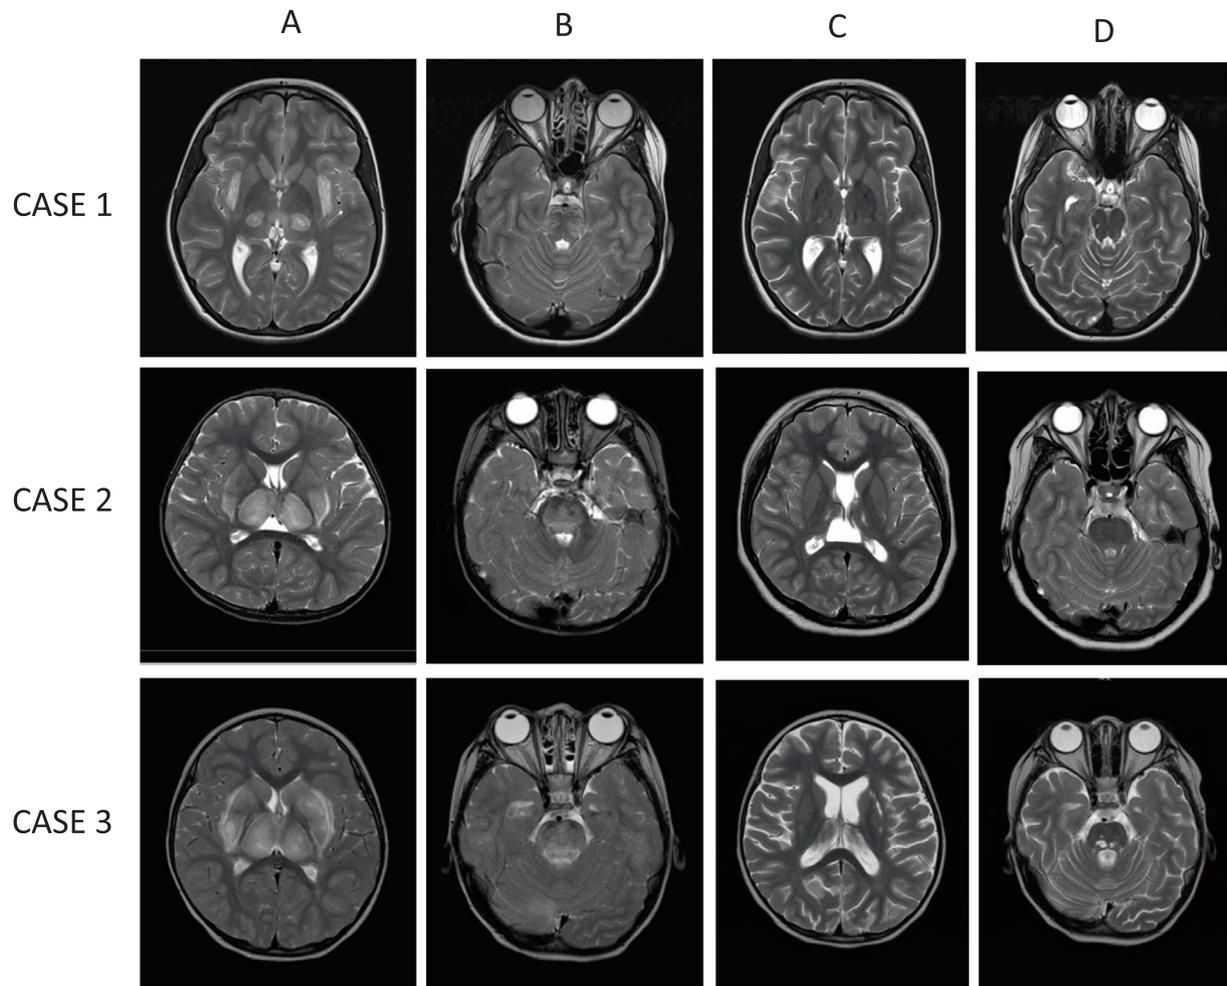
Acute and Convalescent MRI for Cases 1, 2 & 3. Case 1: Axial T2 Weighted MRI scans for the three cases. A: acute through thalamus. B: acute through brainstem. C: convalescent through thalamus. D: convalescent through brainstem. Case 1 (A) – Swelling and hyperintensities noted in bilateral external capsules, lateral putamina and thalami on acute MRI; Case 1(B) – Hyperintensities noted in the midbrain on acute MRI; Case 1 (C) – Resolution of T2W hyperintensities with atrophy of the thalami and some T2W hypointensities in bilateral thalami; Case 1 (D) – Resolution of midbrain T2W hyperintensities on follow up (17 days after first MRI). Case 2 (A) – Marked swelling and hyperintensities noted in bilateral thalami, hyperintensities in bilateral external capsules, posterior putamina on acute MRI; Case 2 (B): Hyperintensities noted in the pons on acute MRI; Case 2 (C) – Resolution of T2W hyperintensities with atrophy of the thalami and some T2W hyperintensities suggesting cystic change in bilateral thalami; Case 2 (D) – Resolution of pons T2W hyperintensities on follow up (6 y 9 m after first MRI). Case 3 (A) – Marked Swelling and hyperintensities noted in bilateral thalami, hyperintensities in bilateral external capsules, caudate nuclei and posterior putamina on acute MRI; Case 3 (B): Hyperintensities noted in the pons on acute MRI; Case 3 (C) – Resolution of T2W hyperintensities with atrophy of the thalami; Case 3 (D) – Residual T2W hyperintensities in the dorsal pons suggesting cystic change on follow up (11 y after first MRI).
